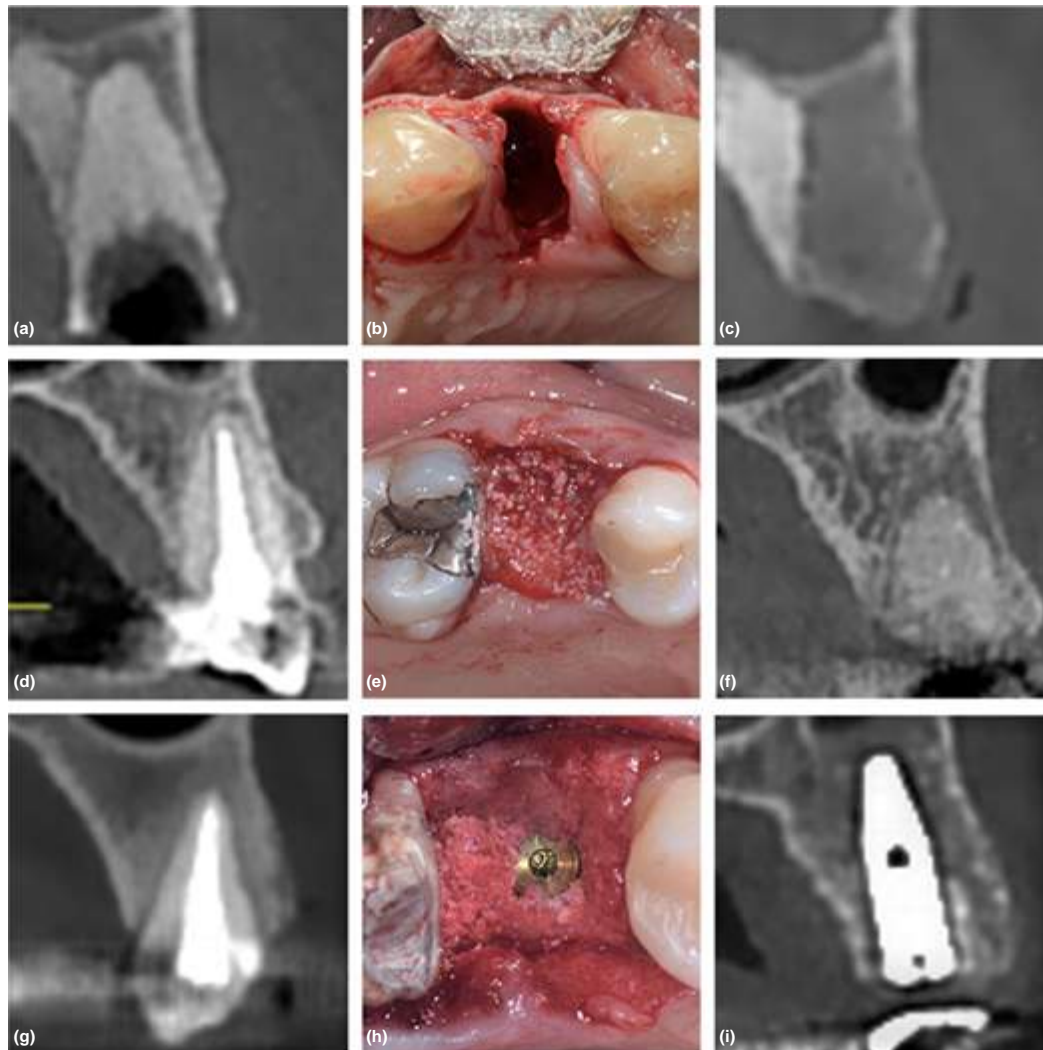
Baseline cone-beam computed tomography (CBCT), intra-operative view and 4 months postsurgery CBCT representative of the three treatment modalities. (1) spontaneous healing: (a) baseline, (b) intra-operative, (c) 4 months. (2) DBBM-CM site: (d) baseline, (e) intra-operative, (f) 4 months. (3) IMPL/DBBM-CM site: (g) baseline, (h) intra-operative, (i) 4 months
